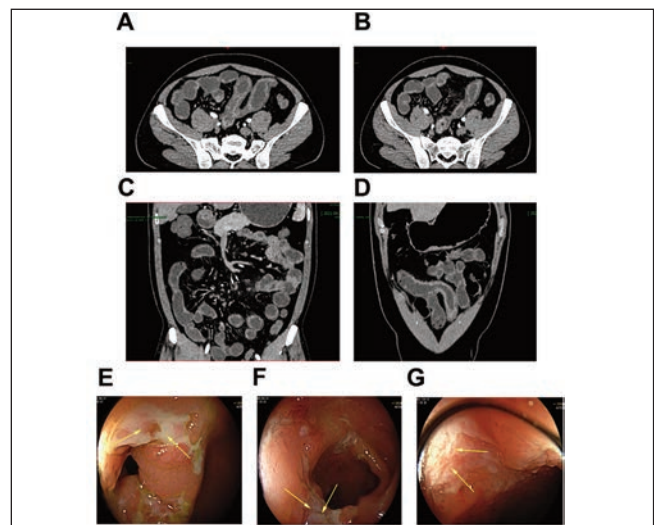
Abdominal enhanced CT scan and Colonoscopy. The abdominal enhanced CT scan revealed thickening of the intestinal wall and stenosis in the middle and end of the ileum and ileocaecum. Enlargement of the mesenteric lymph nodes and thickening of the intestinal wall were observed in the middle of the ileum (A, B, and C). Colonoscopy showed narrowness in the ileocaecal part of the small intestine, with an ulcer covered with white fur, as indicated by the yellow arrow (D, E, and F).
